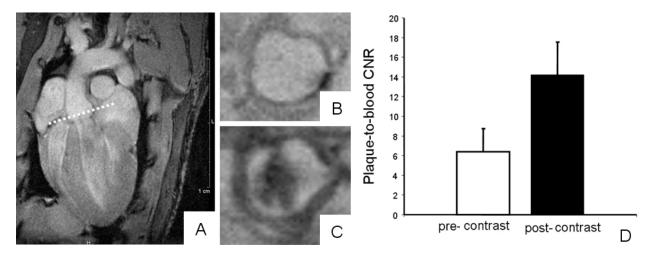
In vivo* MRI. Example of *in vivo* images obtained with T2*-weighted gradient-echo sequences. The dashed line in A displays the image plane through the aortic root. Short axis slices through the aortic root pre-contrast (B) and >48 hours post-contrast (C). Plaque-to-blood CNR increases by 122% (D).
